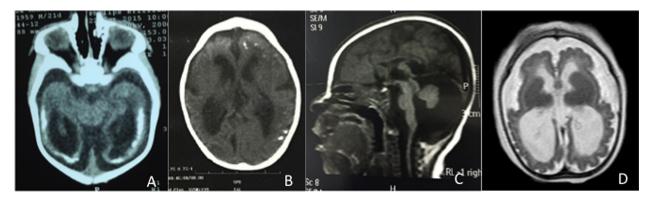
CT scans of different patients identified extensive cortical-subcortical calcifications with an almost band-like pattern (A), or more discrete calcifications at the cortical margins (B), as well as increased ventricular and extra-axial fluid (A and B) and ventricular asymmetry and dysmorphia on coronal images. Sagittal image identifying a thin and incomplete corpus callosum, as well as increased extra-axial fluid with a cystic dilatation of the posterior fossa (C). T2 sequence of brain MRI showing subarachnoid space dilation, ex-vacuo ventricular dilation, and a pattern of simplification of the cerebral cortex with polymicrogyria (D). [Color figure can be viewed at wileyonlinelibrary.com]
